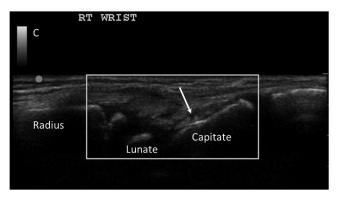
Representative ultrasound images with abnormal findings. A. Lateral longitudinal view of the subtalar joint shows joint effusion (arrowheads) and synovial thickening (arrow). B. Anterior longitudinal view of suprapatellar bursa of the knee joint shows joint effusion (arrowheads). C. Dorsal longitudinal view of the wrist showed positive power Doppler signals (arrow).
